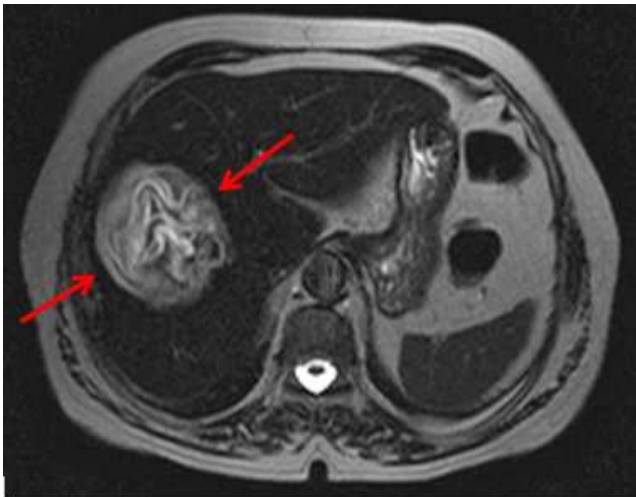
MRI T2W image shows a hyperintense heterogenous cyst hydatid (Gharbi Type 4, WHO CE 4) (arrows) located at right liver lobe.
